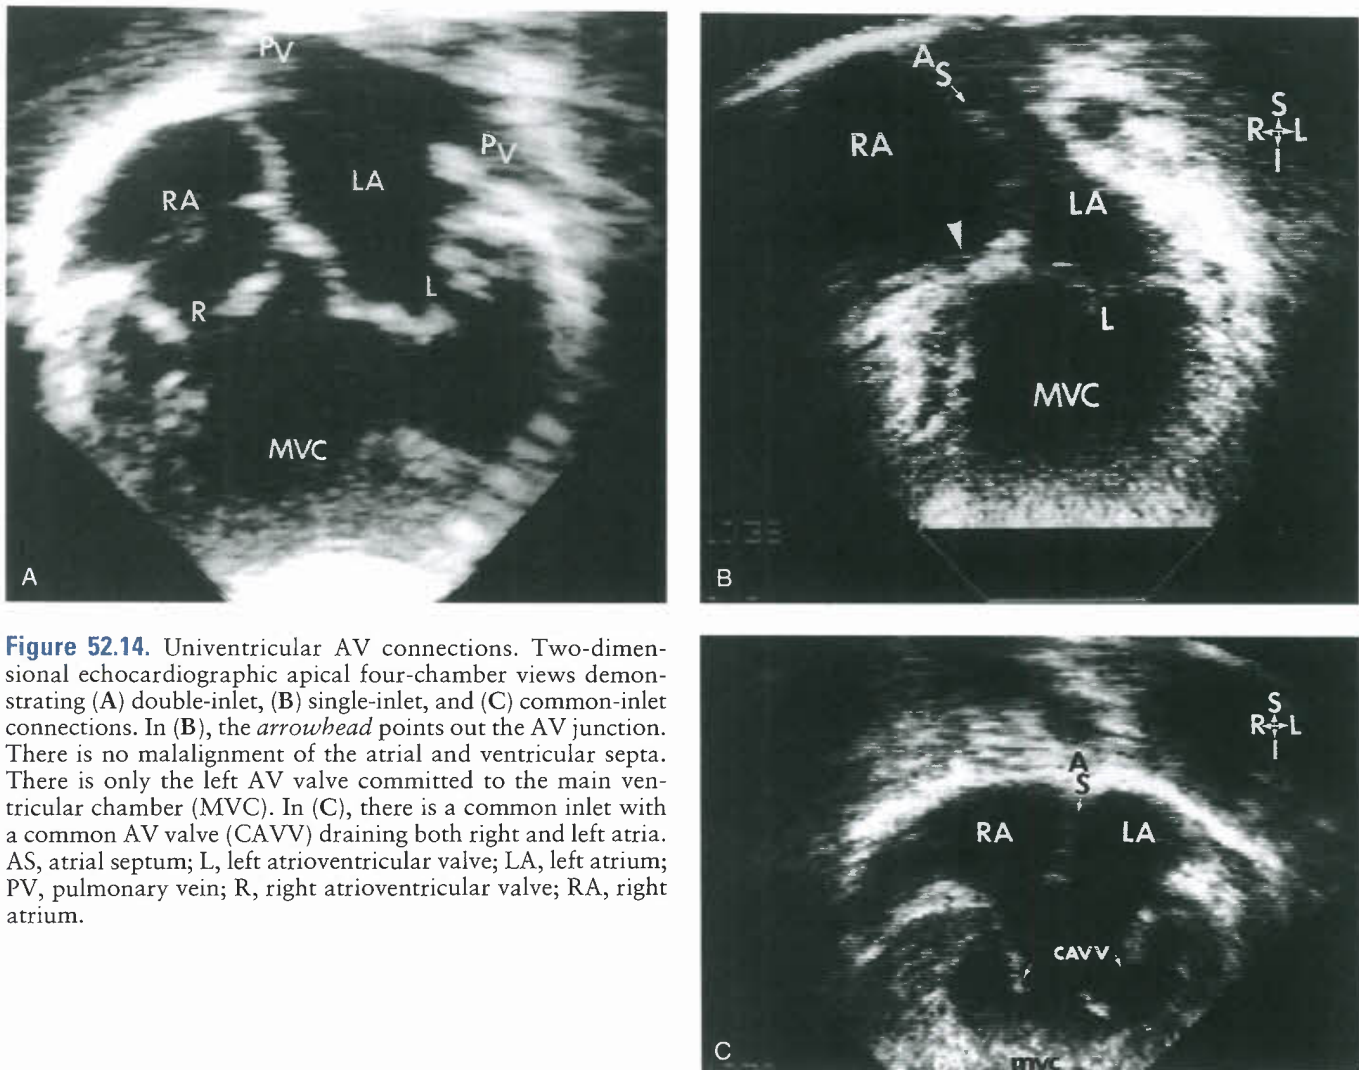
Univentricular AV connections. Two-dimensional echocardiographic apical four-chamber views demonstrating (A) double-inlet, (B) single-inlet, and (C) common-inlet connections. In (B), the arrowhead points out the AV junction. There is no malalignment of the atrial and ventricular septa. There is only the left AV valve committed to the main ventricular chamber (MVC). In (C), there is a common inlet with a common AV valve (CAVV) draining both right and left atria. AS, atrial septum; L, left atrioventricular valve; LA, left atrium; PV, pulmonary vein; R, right atrioventricular valve; RA, right atrium.
